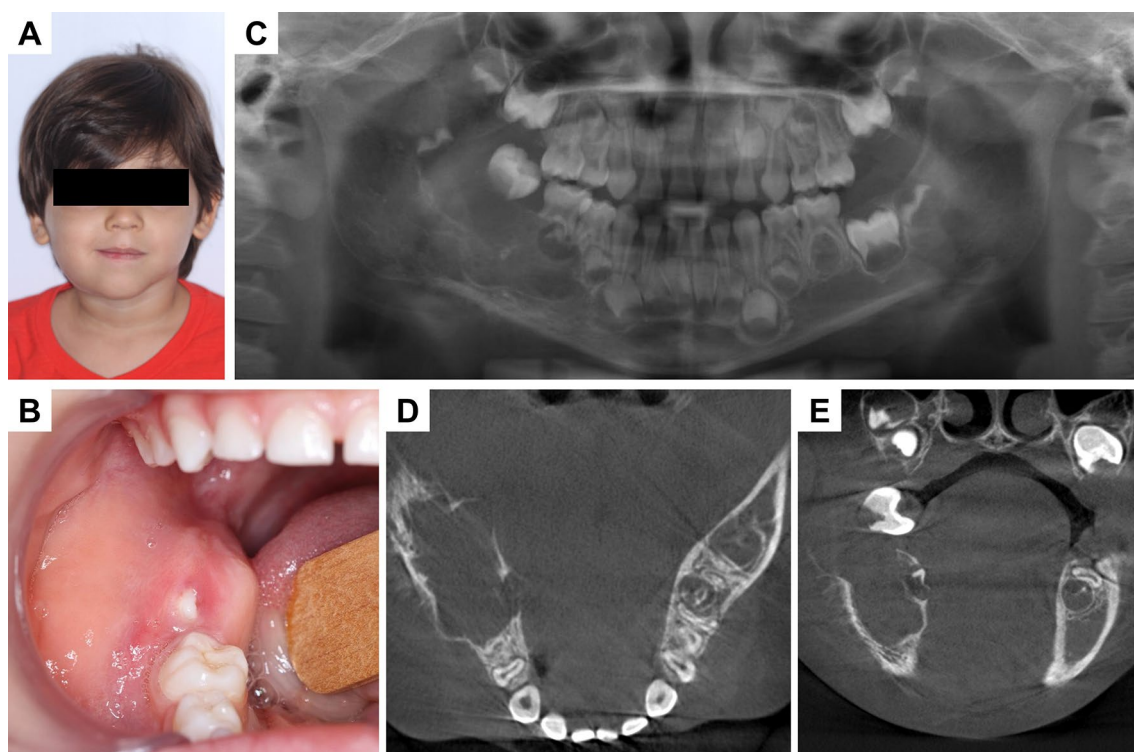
Clinical features of metastatic neuroblastoma (Case 2). a Extra-oral presentation showing facial asymmetry with a right mandibular swelling. b Intra-oral presentation showing prominent vestibular swelling in the right mandibular region. c Panoramic radiographic showing a poorly-defined radiolucency affecting the right
